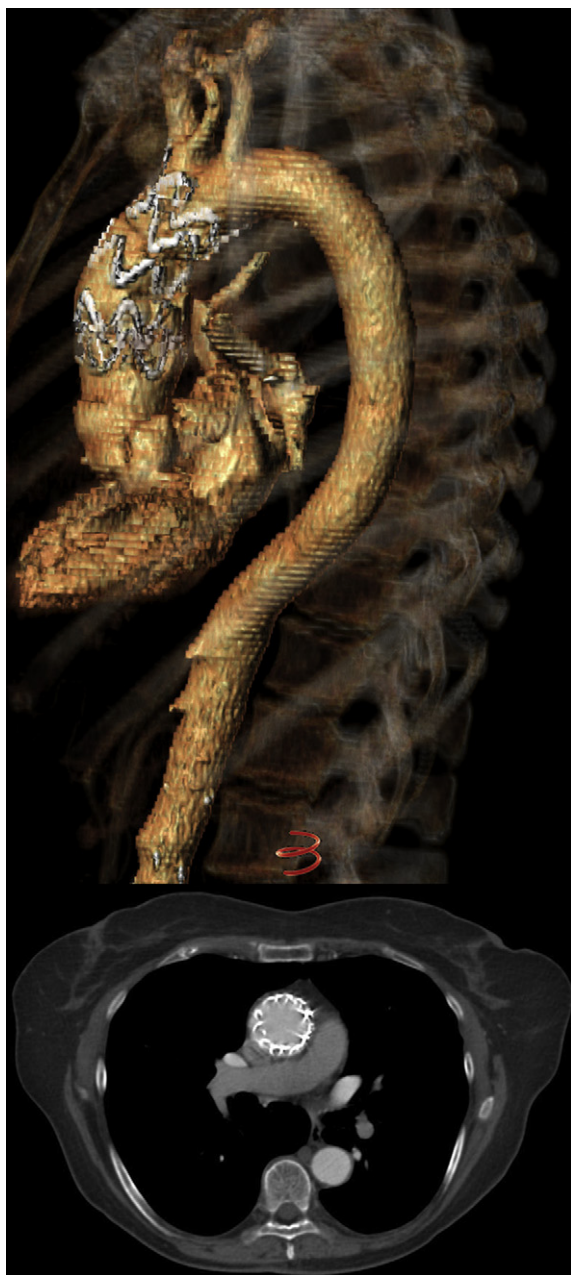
Images demonstrating custom ascending aortic stent in-situ landing proximal to innominate artery [3 month follow-up scan]. Volume rendered 3D reconstruction and axial contrast-enhanced CT image.
